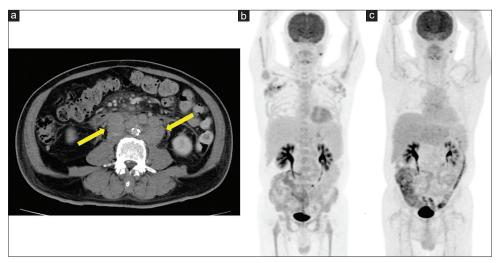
Image work-up of the patient. (a) Contrast-enhanced computed tomography of the abdomen showed retroperitoneal lymphadenopathies (yellow arrow). (b) PET scan showed multiple FDG-avid lesions over neck, axillary, intra-abdominal lymphadenopathies and entire skeleton (c) PET scan showed a good metabolic remission after the completion of R-COP treatment. PET: Positron emission tomography, R-COP: Rituximab, vincristine, cyclophosphamide, and prednisolone
